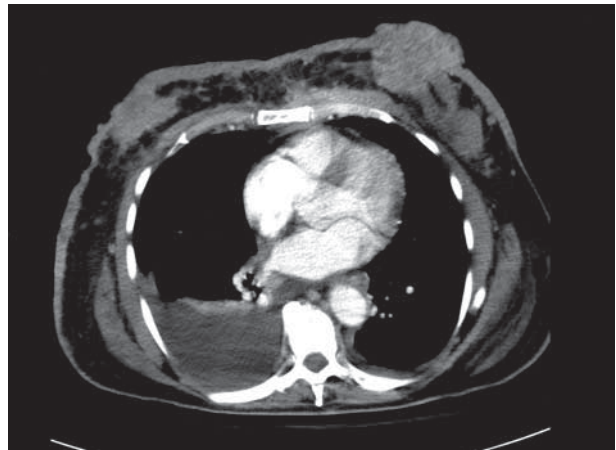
Computed tomographic scan of the chest.
